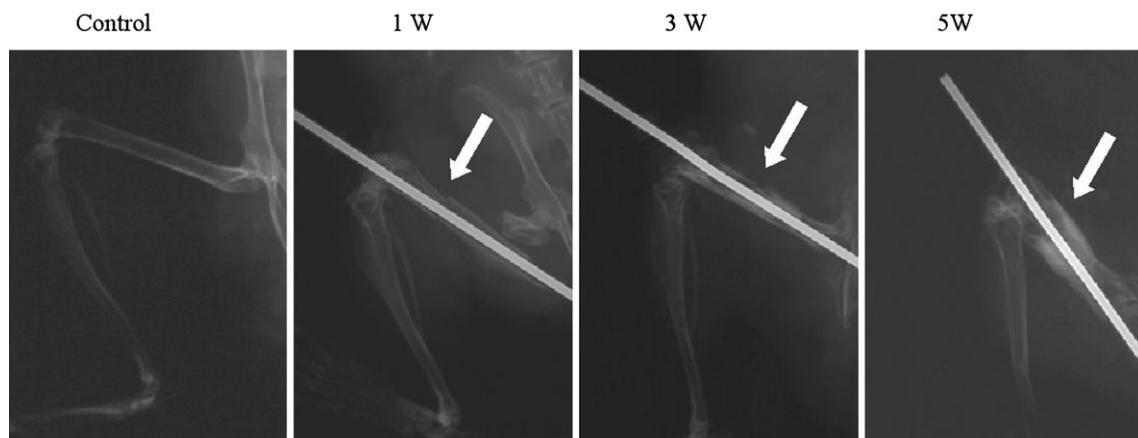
Time course of X-ray study. X-ray examinations were performed 1, 3, and 5 weeks after fracture. Callus formation was observed after 3 and 5 weeks, with much larger calluses at 5 weeks than at 3. Arrows indicate the fracture site.
